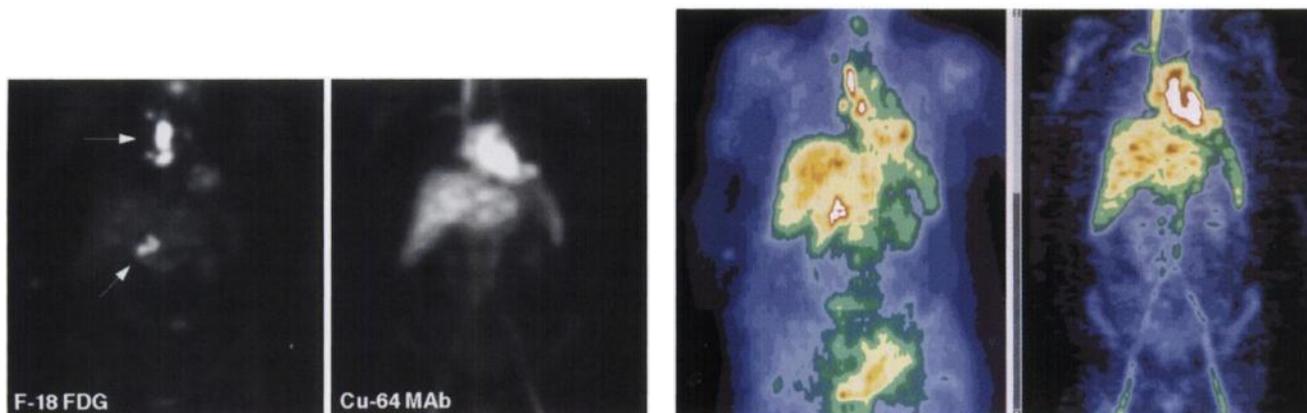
Anterior volume-rendered reprojection PET images, obtained after injection of FDG (left, 10 mCi) and ^{64}Cu -MAb 1A3 (right; 10 mCi, 20 mg), in a woman postresection of Dukes' C rectal cancer 1 yr before enlarged mediastinal and periportal lymph nodes were observed. These nodes were strongly positive on FDG-PET (left panel) but were completely negative on ^{64}Cu -MAb 1A3-PET (right panel). Subsequent biopsy of the lymph nodes demonstrated sarcoidosis.
